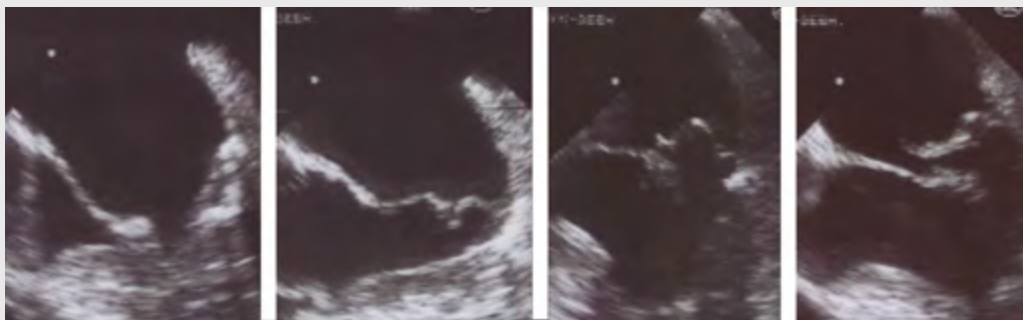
Transesophageal echocardiogram of mitral valve prolapse.
